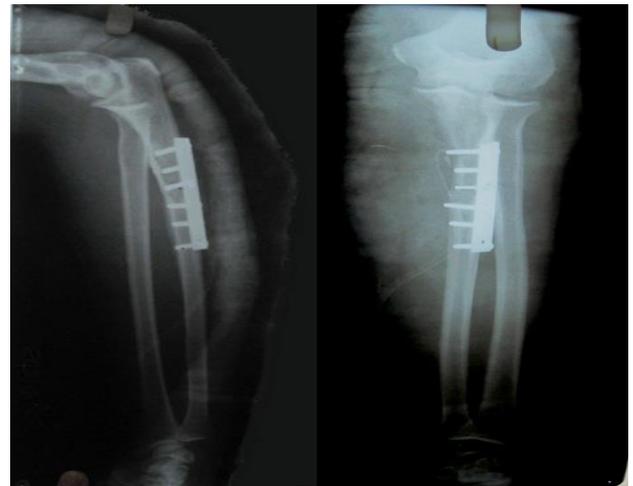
Post-operative X-rays at 12 weeks showing union.
